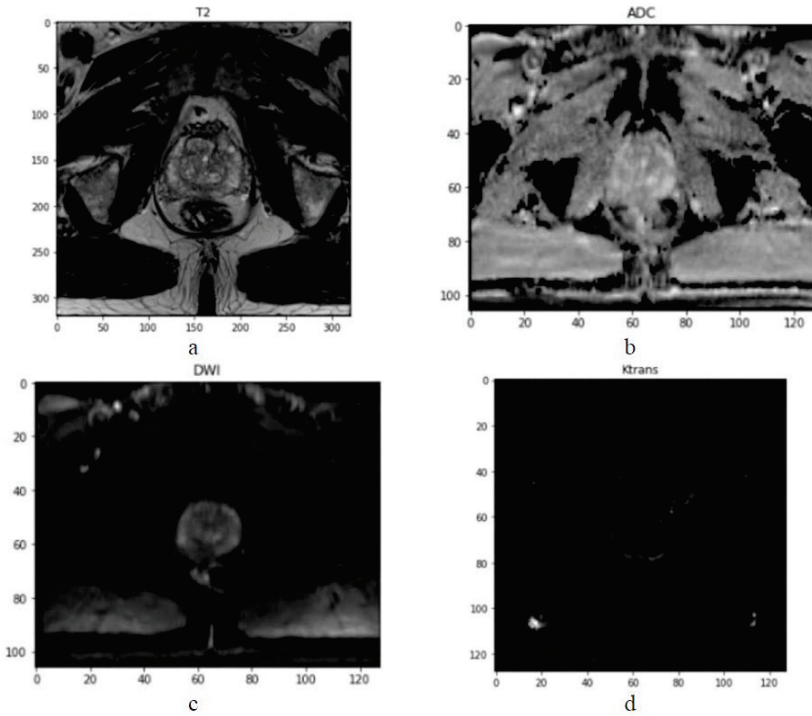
(a) a T2W slice, (b) an ADC slice, (c) a DWI slice, and (d) a Ktrans slice
